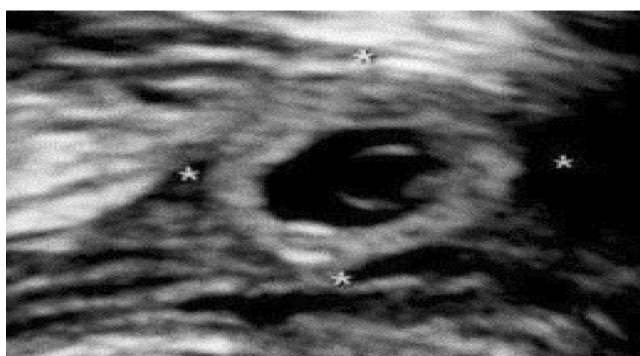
Sonographic image of the tubal pregnancy at the right fallopian tube.
